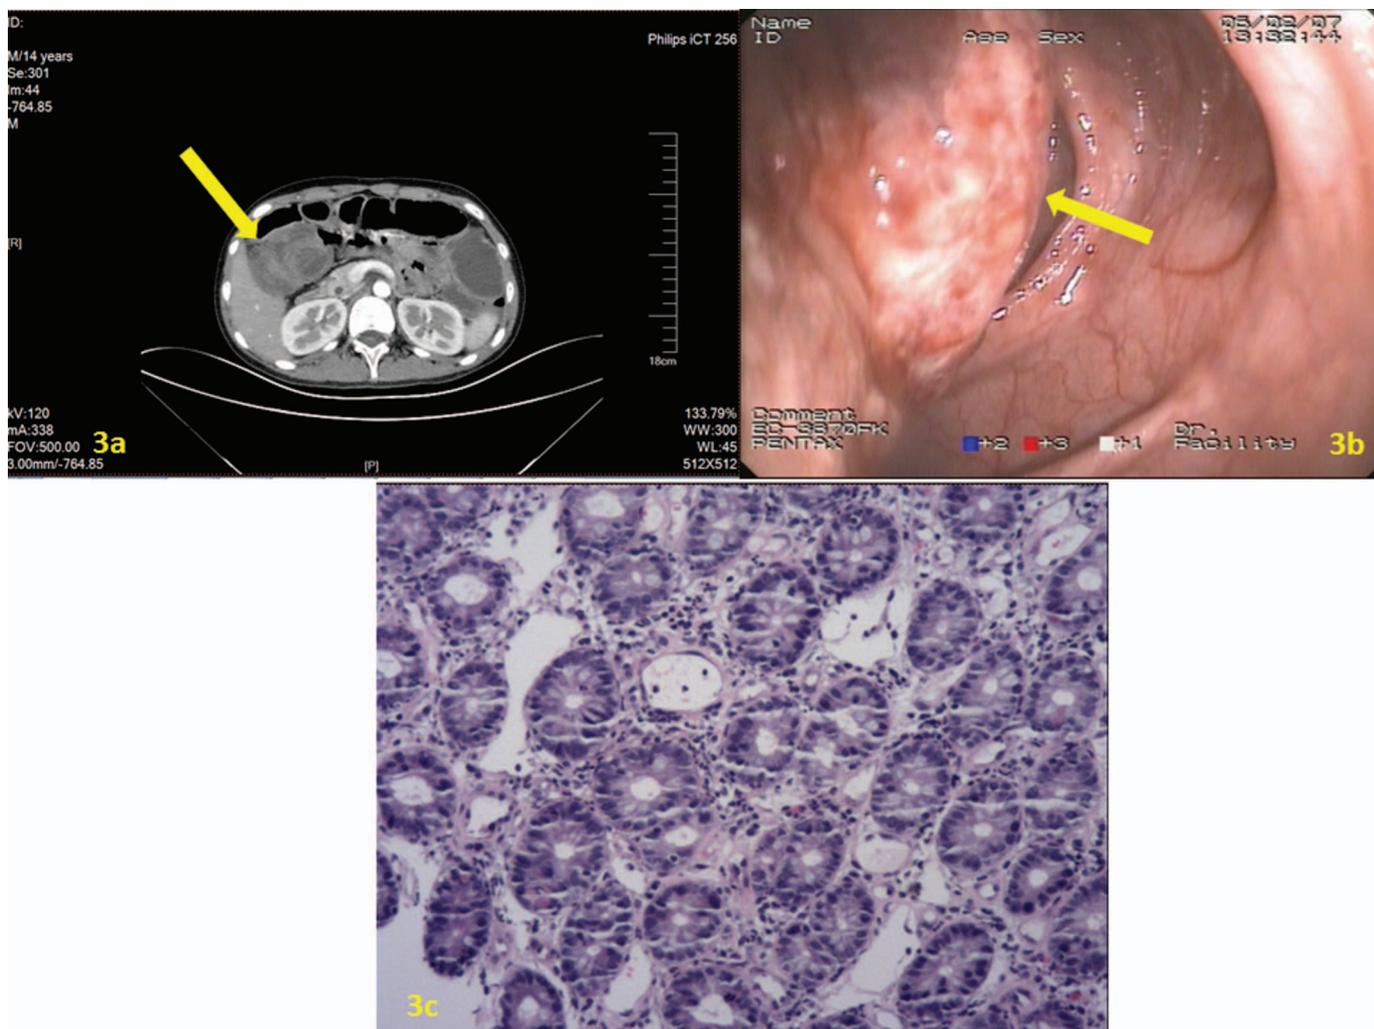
Abdominal computed tomography (CT) showed ileocolic intussusception (Figure 3A, yellow arrow). Colonoscopy revealed a polyp lesion (Figure 3B, yellow arrow). Biopsy of the intestinal mucosa showed inflammatory changes (Figure 3C).
